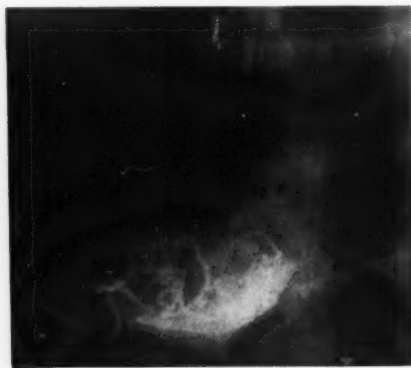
A non watery opaque substance. When safe particulate agents (not necessarily solid but capable of producing punctate areas of radiopacity) are achieved, there will result a tremendous expansion of the applications of angiocardiography to the fundamental and clinical investigation of the cardiovascular system. Very short, precisely timed x-ray exposures will be essential.*
